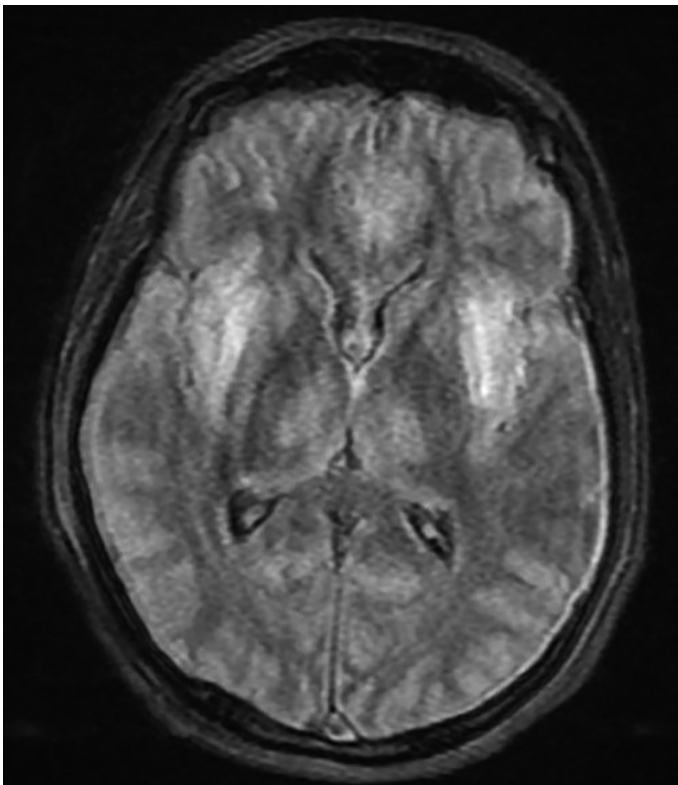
Cerebral edema in initial T2 FLAIR MRI.
